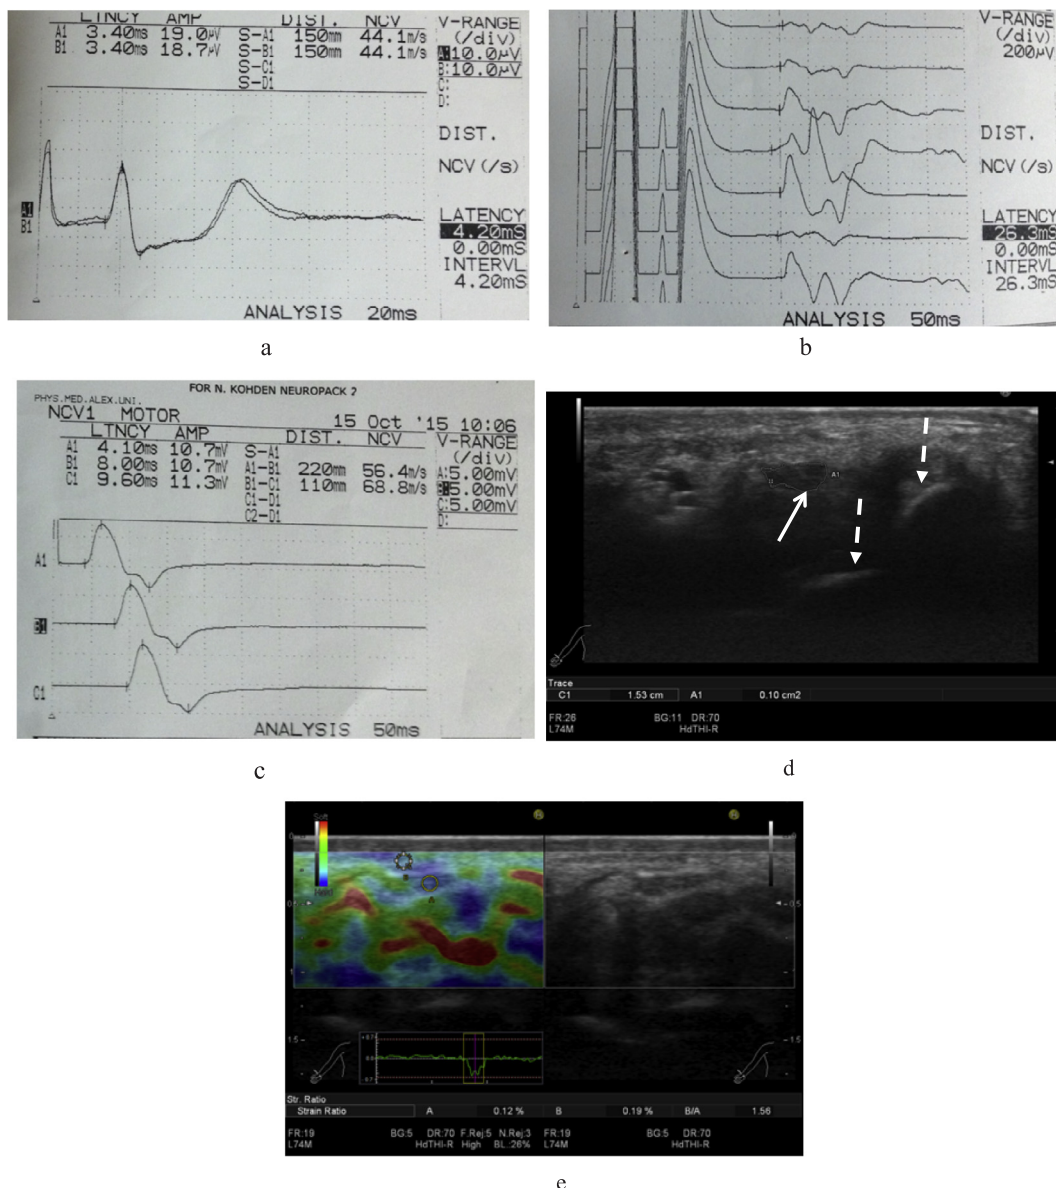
Female patient 32 years diagnosed as mild degree of CTS by EPS (a–c) Sensory conduction antidromic study of the left median nerve showing prolonged peak latency (4.2 ms), normal amplitude (19 µV) and slowing of nerve conduction velocity (44.1 m/s). Motor conduction study of the left median nerve showing normal distal latency (4.1 ms), normal amplitude (10.7 mV) and normal nerve conduction velocity across forearm segment (56.4 m/s). Normal F-response of the left median nerve with minimal latency = 26.3 ms. Normal Sensory and Motor conduction studies of the left ulnar nerve showing normal distal latency, amplitude and nerve conduction velocity. (d) Grey scale ultrasound of the median nerve at the wrist (scaphoid and pisiform level: dashed arrows) showed cross sectional area of the median nerve = 10 mm² (white arrow). (e) Elastography of the median nerve showed strain ratio = 1.56.
